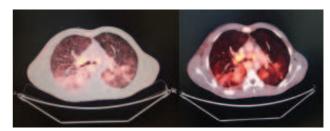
PET-CT showing multiple metabolically active lesions suggestive of lymphangitis carcinomatosis in both lungs.
